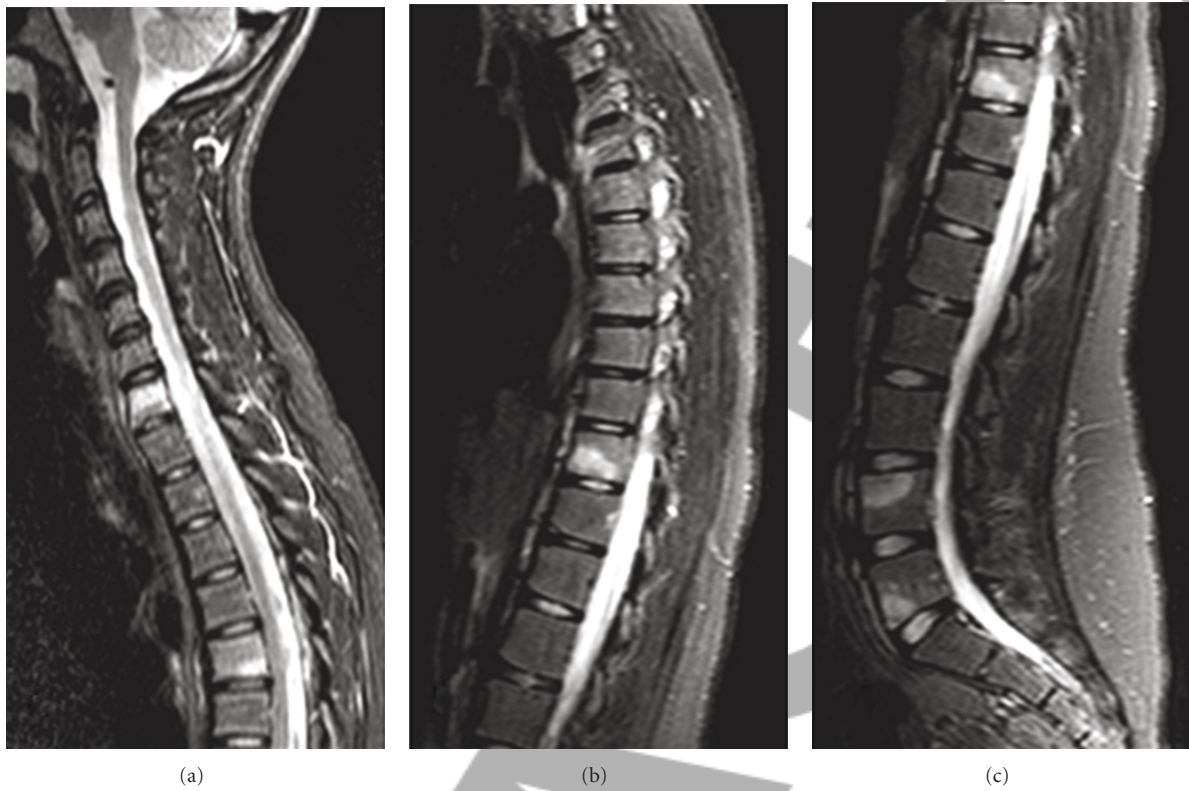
MRI of the spine at the disease presentation. Multiple vertebrae lesions are demonstrated in the cervical, thoracic, and lumbar spine, which exhibit increased signal intensity on sagittal T2-weighted images (a), (b), and (c). The appearance of the intervertebral discs is normal.
